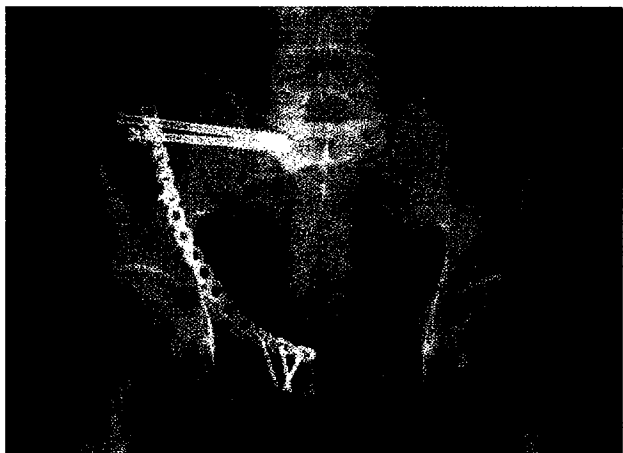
CT control 3 months after revision surgery and partial weight bearing of the patient. There is correct positioning of the two inserted screws without loosening and ingrowth of the autologous bone grafting with subsequent osseous union.
